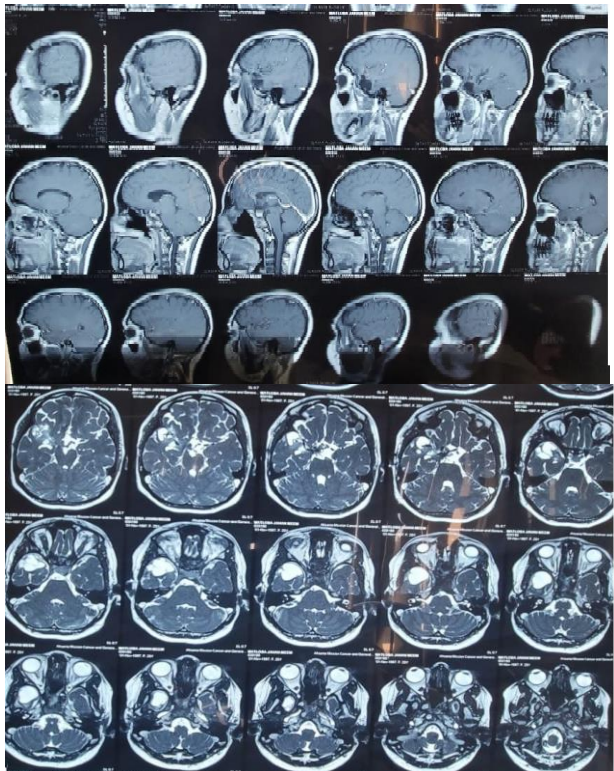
MRI comparative study was done which showed partial regression of disease compared to last scan and this time there was mild heterogeneously enhancing lesion (1.8×1.2×1.5 cm) at the site of operation with further reduced compression on optic chiasma and right optic nerve.
